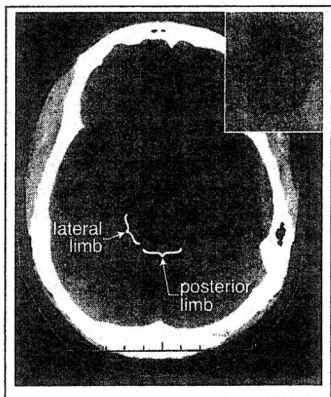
Basal cisterns CT demonstrating open basal cisterns (inset: example of = complete obliteration of BCs)
